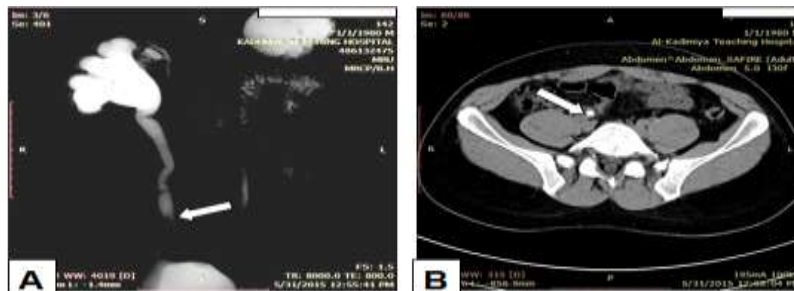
35 years old male with 12 hr. duration of severe Rt. Renal colic. A: HASTE MRU showing severe hydronephrosis and hydroureter caused by lower ureteric stone (arrow). B: axial unenhanced CT showing the lower ureteric stone (arrow).
